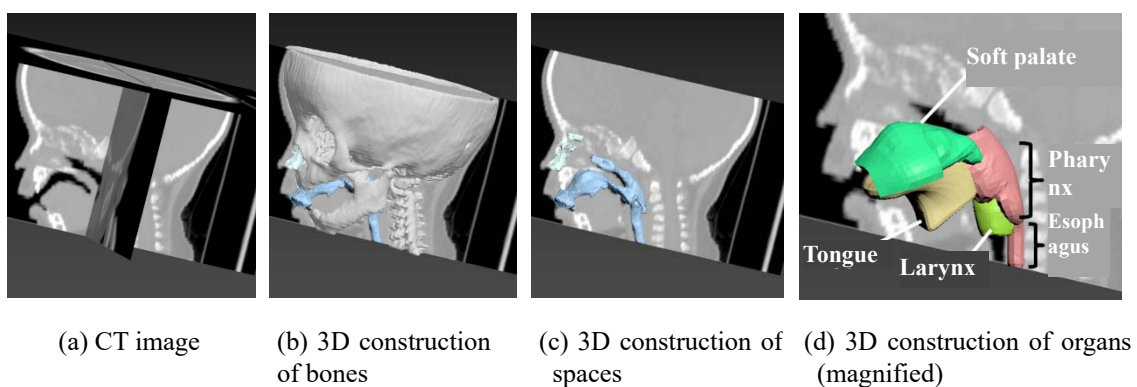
Method of creating surface geometries of organs based on CT images from a 9-month-old child
